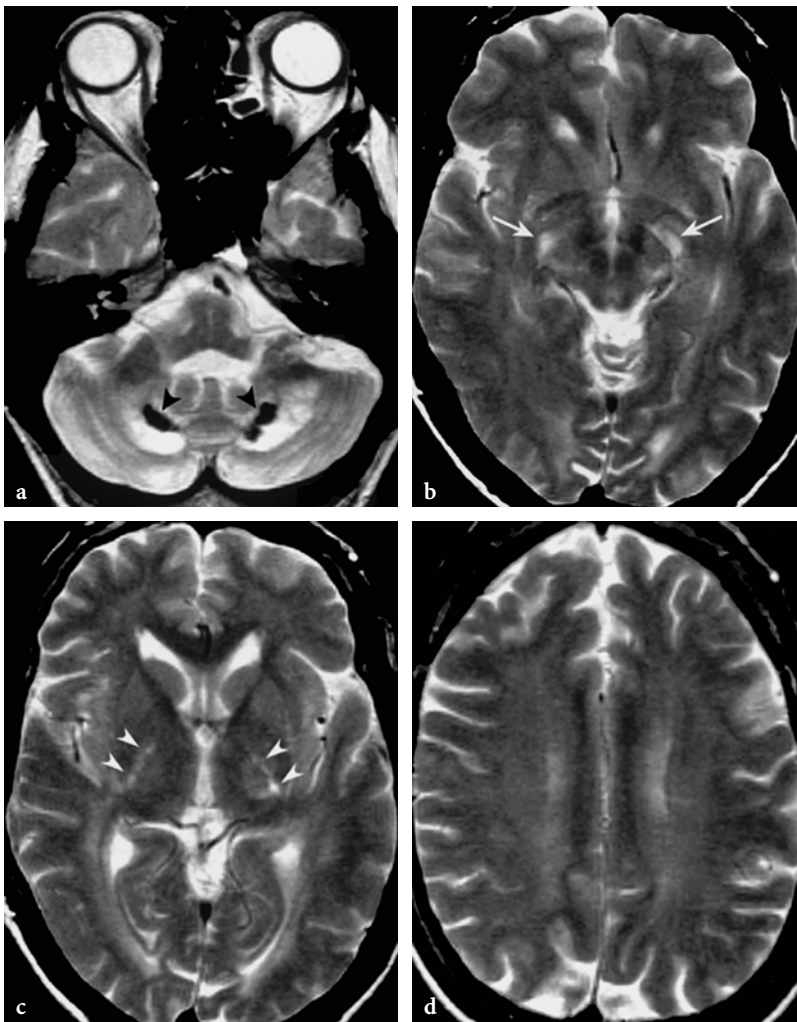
MR imaging findings in cerebrotendinous xanthomatosis (courtesy of Dr. F. Barkhof, Amsterdam, The Netherlands). a-d Axial T2-weighted spin-echo images. At the level of dentate nuclei prominent hypointensities are seen (*arrowheads*, a) but the adjacent cerebellar white matter is also abnormal. Signal changes are present within the substantia nigra (*arrows*, b) and posterior limbs of the internal capsules (*arrowheads*, c), and faint hyperintensities are also suggested within the centrum semiovale (d)
